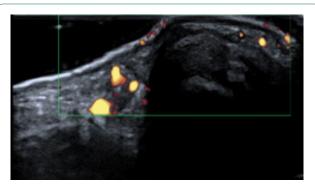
Ultrasound with Doppler of patient's left hand (both hands were scanned) showing no evidence of synovitis.
